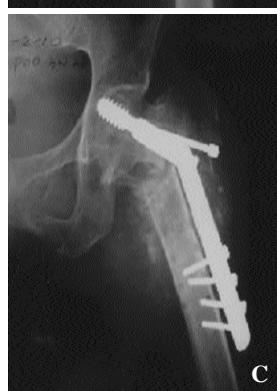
Preoperative roentgenogram of 67 years old female, Evans classification (displaced not reduced) and Singh index
